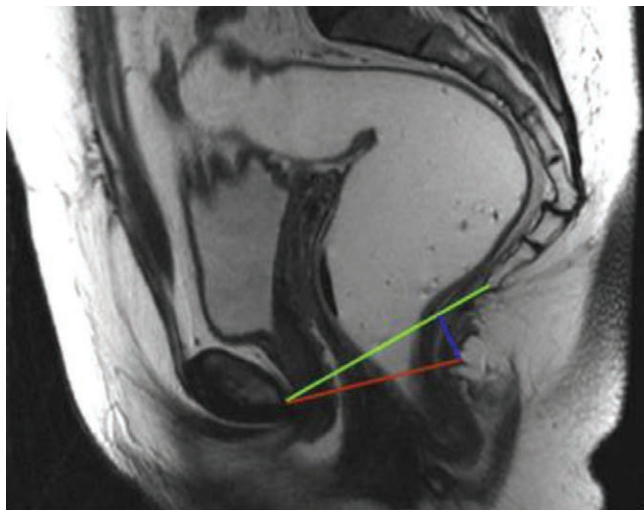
Pubococcygeal (green) line is the line drawn between the lower part of the pubis and the lowest coccygeal joint. H (red) line is the line drawn from the lower portion of the pubis symphysis to the posterior wall of the rectum. M (blue) line is the line drawn from the pubococcygeal line to the H line. Reprinted with permission from Magnetic Resonance Imaging Clinics of North America 2013;21:427–445.
